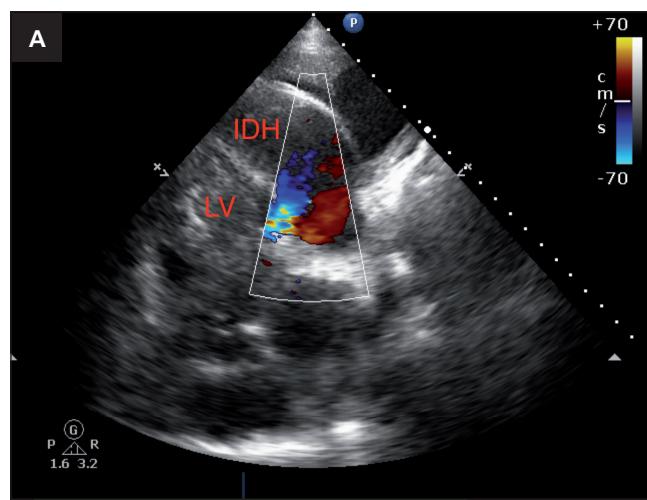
(A) and (B) – To-and-fro flow inside the cavitation of the LV wall (IDH) confirmed by Doppler ultrasonography. IDH – intramyocardial dissecting hematoma; LV – left ventricle.
